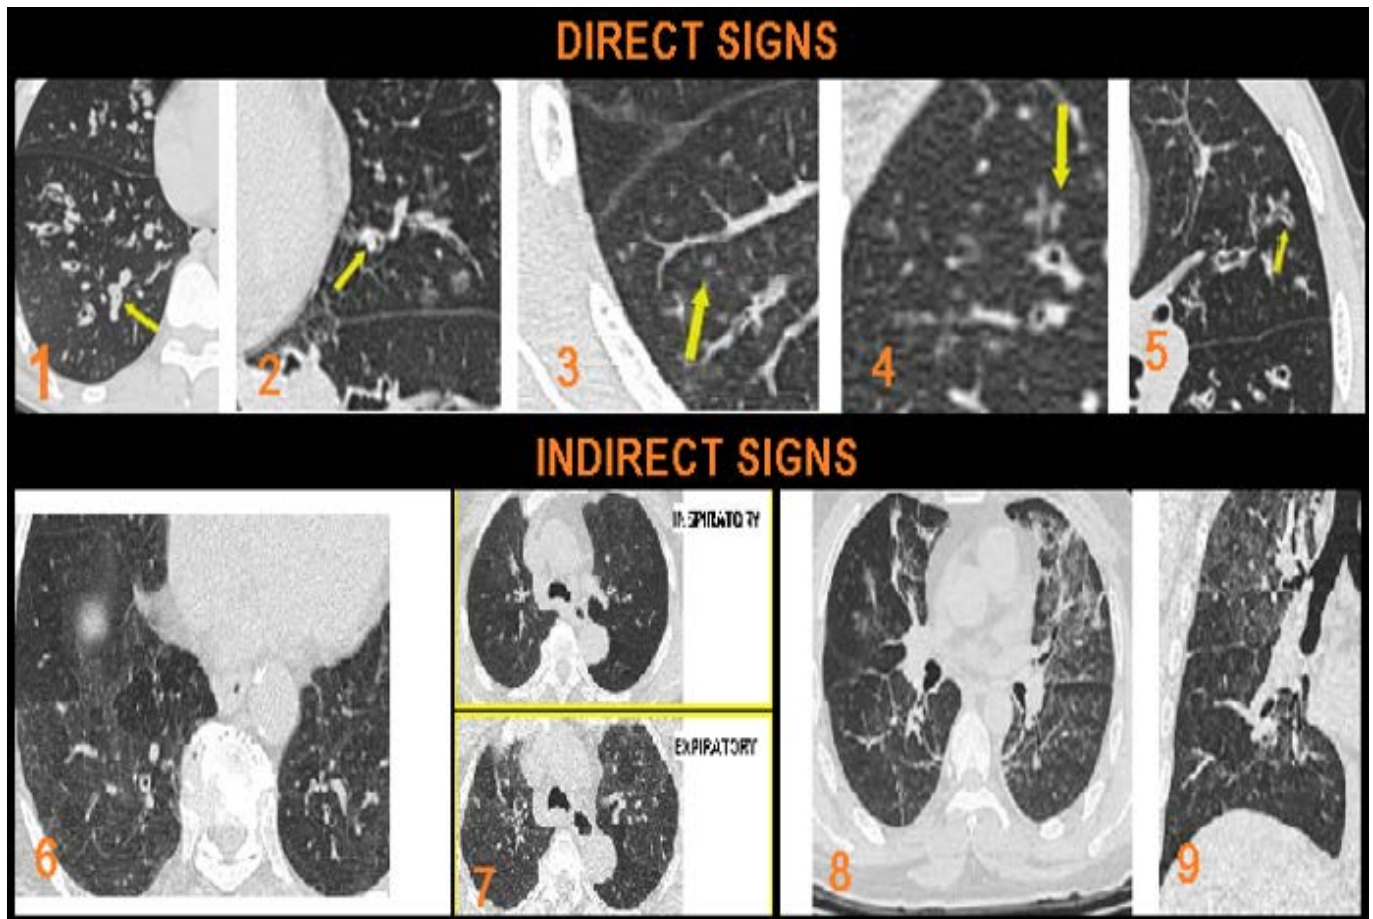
Direct signs of small airway disease include Bronchiolar wall thickening (1), plugs (2), Centrilobular Nodules (3), which are either ill-defined ground glass opacity or well-defined centrilobular branching V or Y nodules, Tree-in-bud opacities (4),Bronchiectasis (5). Indirect signs of small airway disease include Mosaic pattern of attenuation on inspiratory CT scan (6) and air trapping on expiratory CT scan (7), Vascular attenuation (8), Increased lung volume & Subsegmental atelectasis (8,9)
